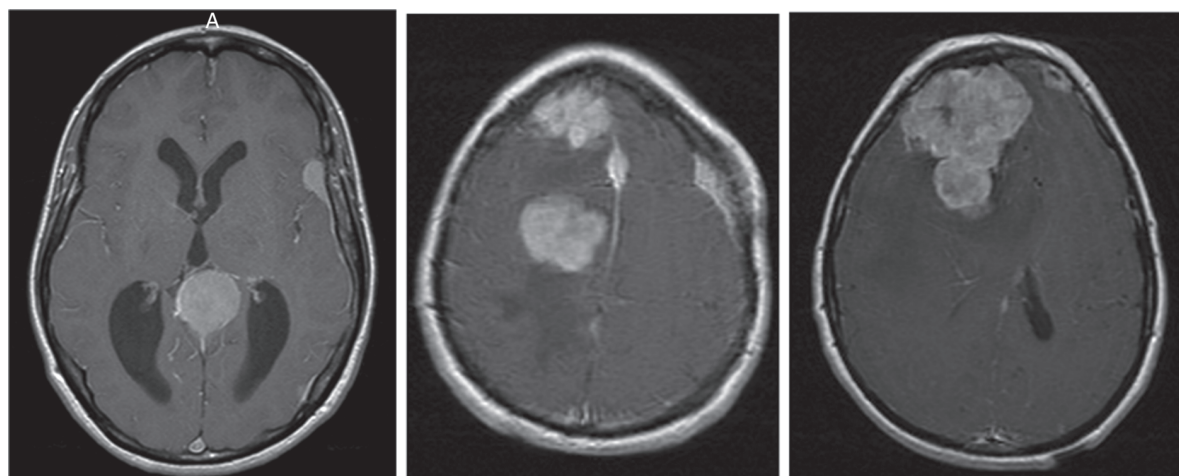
(Left) MRI of sporadic multiple meningiomas; 1 large symptomatic tumor requiring treatment and 1 small tumor to be observed. (Right) MRI scans of radiation-induced multiple meningiomas.
